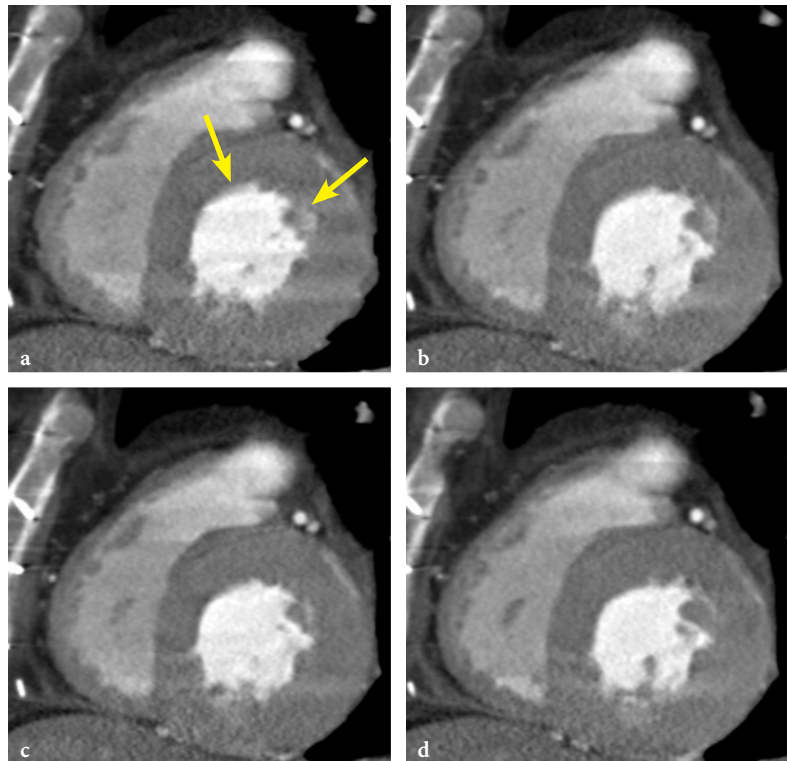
Case example of a cardiac CT angiography examination for a patient with a heart rate of 100–107 bpm using a 64-slice CT scanner with 64×0.6 -mm slices and 0.33-s rotation time. Images are reconstructed during the systolic phase with a relative delay of 25% of the RR-interval, and MPRs are generated in the short heart axis. With single-segment reconstruction and a temporal resolution of 165-ms, motion artifacts are present (a, arrows). Adaptive-segmented reconstruction with 2 (b), 3 (c), and 4 (d) segments improves temporal resolution up to 60 ms, and cardiac anatomy can be visualized during phases of rapid cardiac motion. A substantial image quality improvement takes place when using two segments instead of one. Further image quality improvements are only minor when using more than two segments. (Cases courtesy of Klinikum Grosshadern, University of Munich, Germany)
